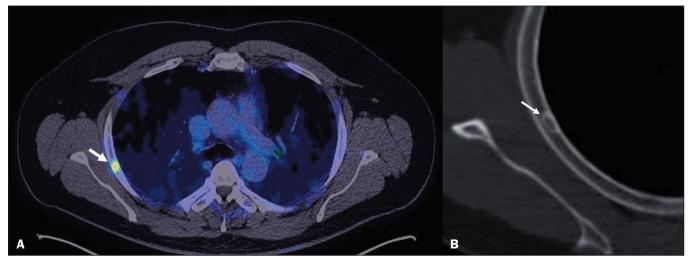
⁶⁸Ga-PSMA PET/CT of a 52-year-old male patient with biochemical recurrence, showing focal uptake (SUVmax, 5.2) in a small hypoattenuating lesion with well delimited sclerotic borders in the lateral segment of the 4th right rib (arrows in A and B). This lesion was comparatively stable in relation to previous studies performed five years before and was therefore characterized as a fibrous cortical defect.
